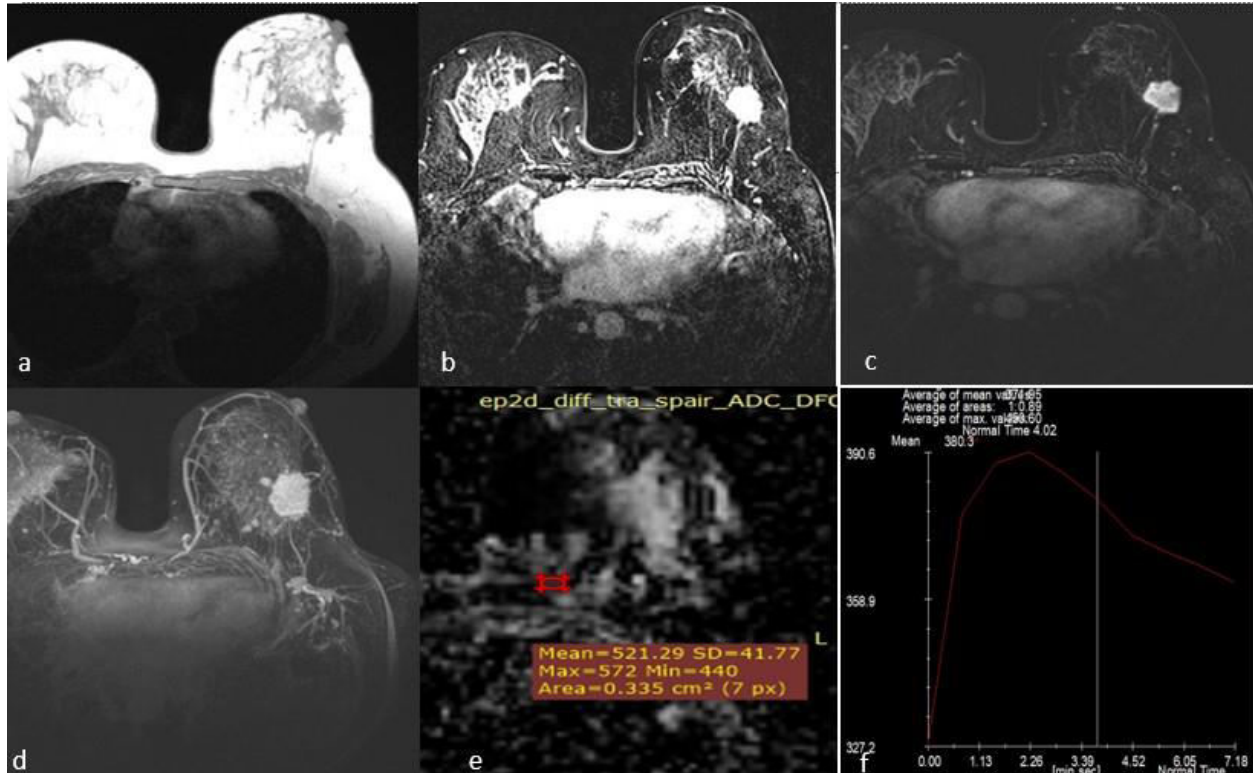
A 58 – year – old female patient, presented clinically with left breast cancer. Pathologic analysis revealed infiltrating duct carcinoma (IDC), grade 2, ER+, PR+, HER 2 neu -, and Ki-67 = 20%. MRI revealed a: T1-weighted image shows an ill-defined hypointense soft mass lesion in the lower outer quadrant with irregular shape and lobulated border; b: post-contrast T1-weighted image shows homogenous intense enhancement, c: STIR image (Short Tau Inversion Recovery) shows hyperintense signal intensity, d: MIP (maximum intensity projection) post-contrast image shows hypervascular lesion; e: ADC map shows mean ADC value for the mass = 0.95 mm<sup>2</sup>/s and mean ADC value for lymph node = 0.7 mm<sup>2</sup>/s; f: type II curve with plateau pattern.
